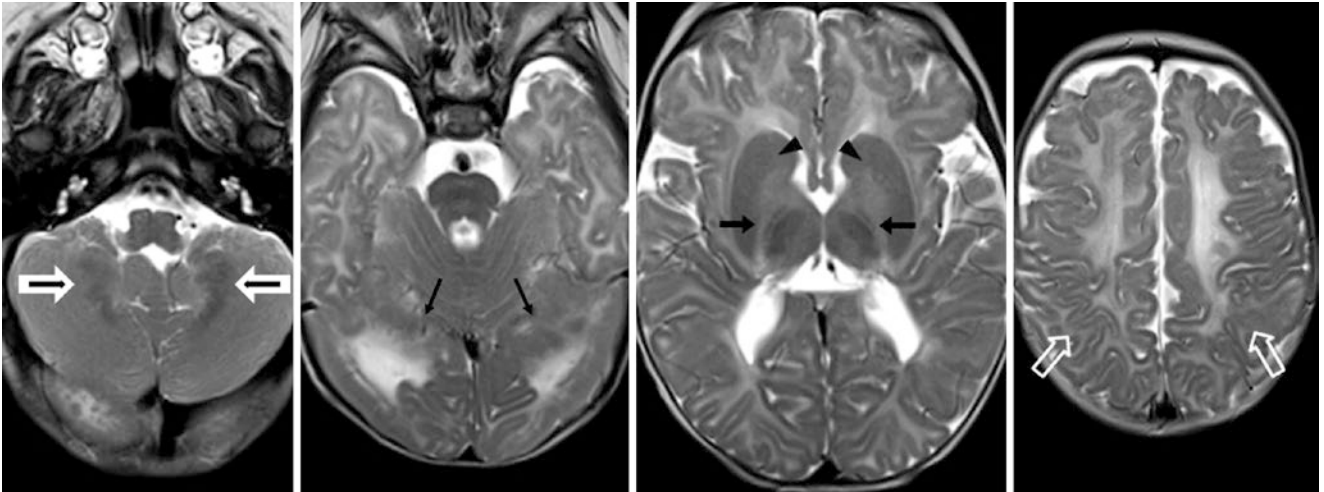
Comparison case of hypomyelination in congenital muscular dystrophy (unknown type). A 6-month-old with seizures had a 1.5T MRI with SE T2WIs. The ALICs (*arrowheads*) and the CG (*not shown*) were not myelinated. The PLIC (*arrows*) was too small and largely
